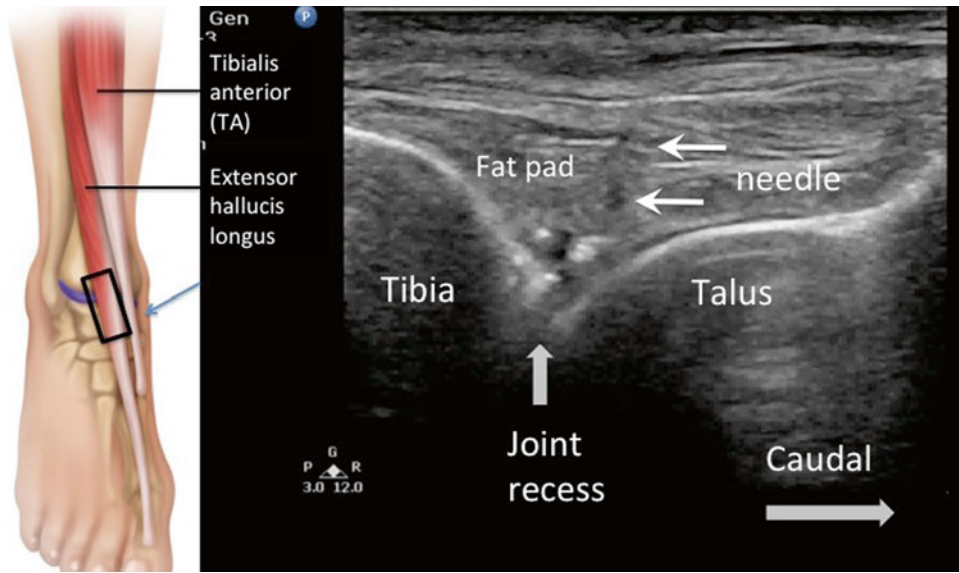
Sonogram shows out-of-plane needle insertion for tibiotalar joint. The *line arrows* indicate the needle path. The insert shows the anatomy and the ultrasound probe position (Reproduced with permission from Philip Peng Educational Series)
